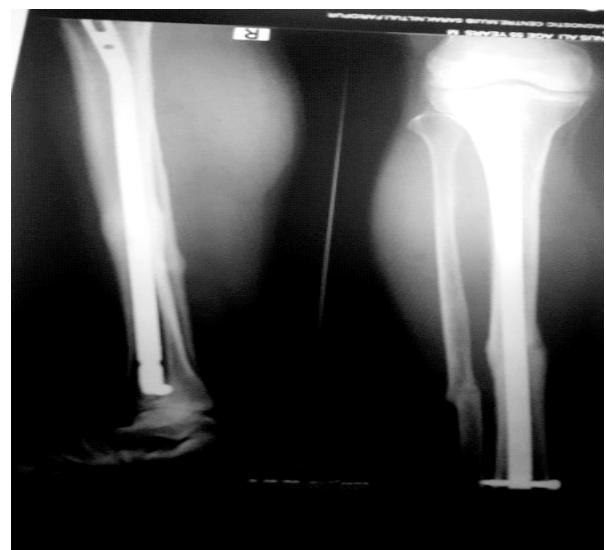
Radiograph at 12 week
